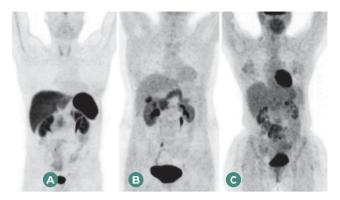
Physiological biodistribution of [68Ga]Ga-DOTATATE, [18F]F-DOPA and [18F] F-FDG. PET 68Ga-DOTA-PEPTIDES. B) PET 18F-DOPA. C) PET 18F-FDG.
